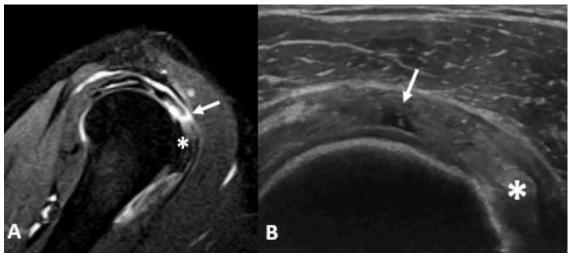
A- Sagittal T2 fat saturated MRI demonstrating a full thickness tear of the supraspinatus tendon with partial thickness tearing as well. B- Transverse diagnostic ultrasound in the same patient showing the focal tearing of the supraspinatus.
